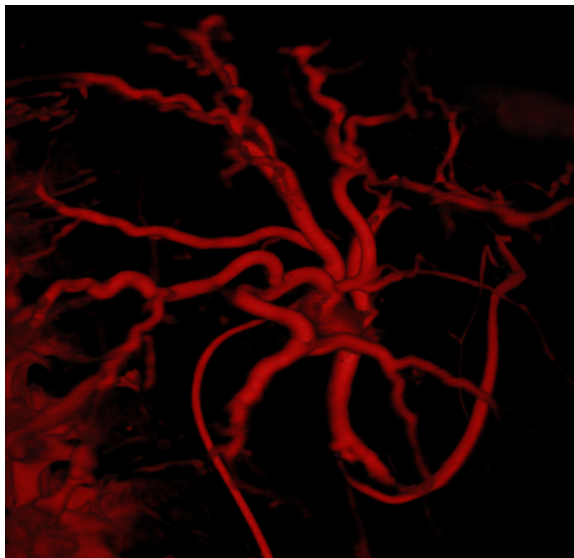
X-ray contrasted image for blood vessels, commonly called X-ray angiography. Through image subtraction contrasted blood vessels become visible. In this particular example, blood vessel tree of liver is visualized in a 3D render mode. Image courtesy of Dr. Martin Groher, Chair for Computer-Aided Medical Procedures, TUM [121].
